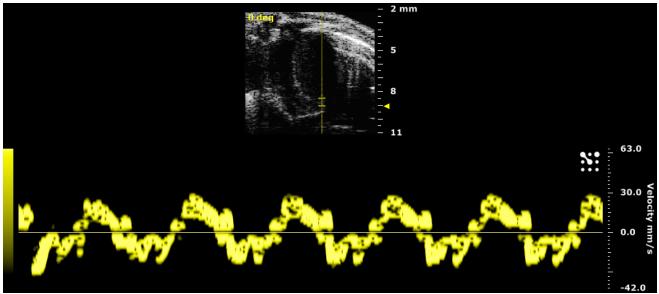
PW Tissue Doppler display of tissue motion at the MV annulus.
